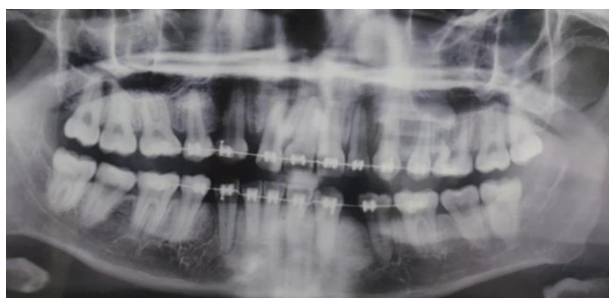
Radiographic imaging showing vertically full erupted tooth 48 and 38.
